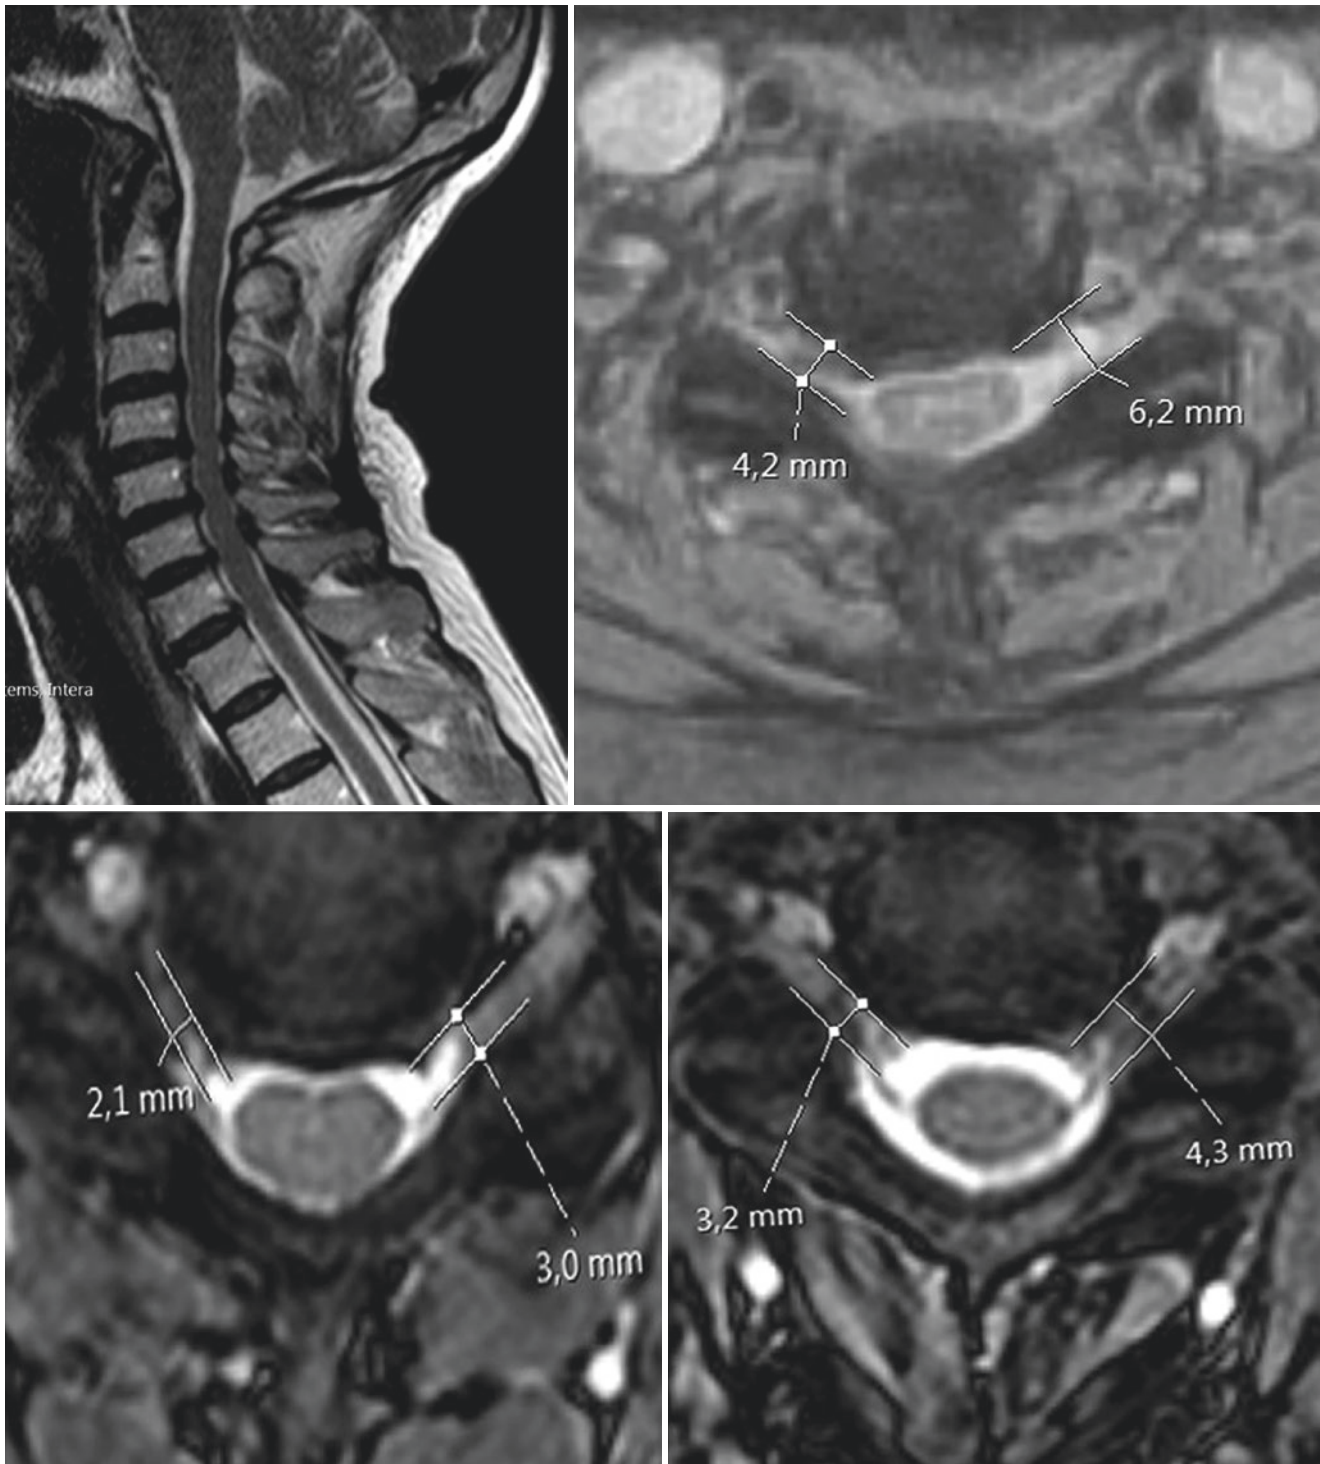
T2-weighted images of a patient with cervical spondylosis presenting with complaints of cervical radiculopathy and arm and neck pain: from left to right and top to bottom are shown magnetic resonance
